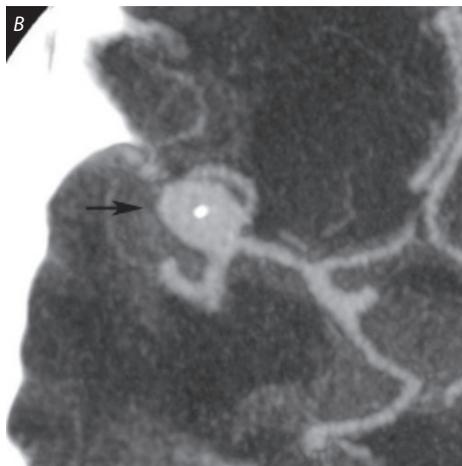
These images show non-contrast CT (a and c) and corresponding CTA (b and d) in two different SAH patients. The non-contrast CT has been performed with the same protocol, the CTA was performed with 120kVp in the patient in (b) and with 90kVp in the other patient in (d). Both CTA images are a 20mm thick slab-MIP with equal window width/level setting at 470/200, demonstrating that 90kVp resulted in increased visibility of vascular structures surrounded by subarachnoid blood.
